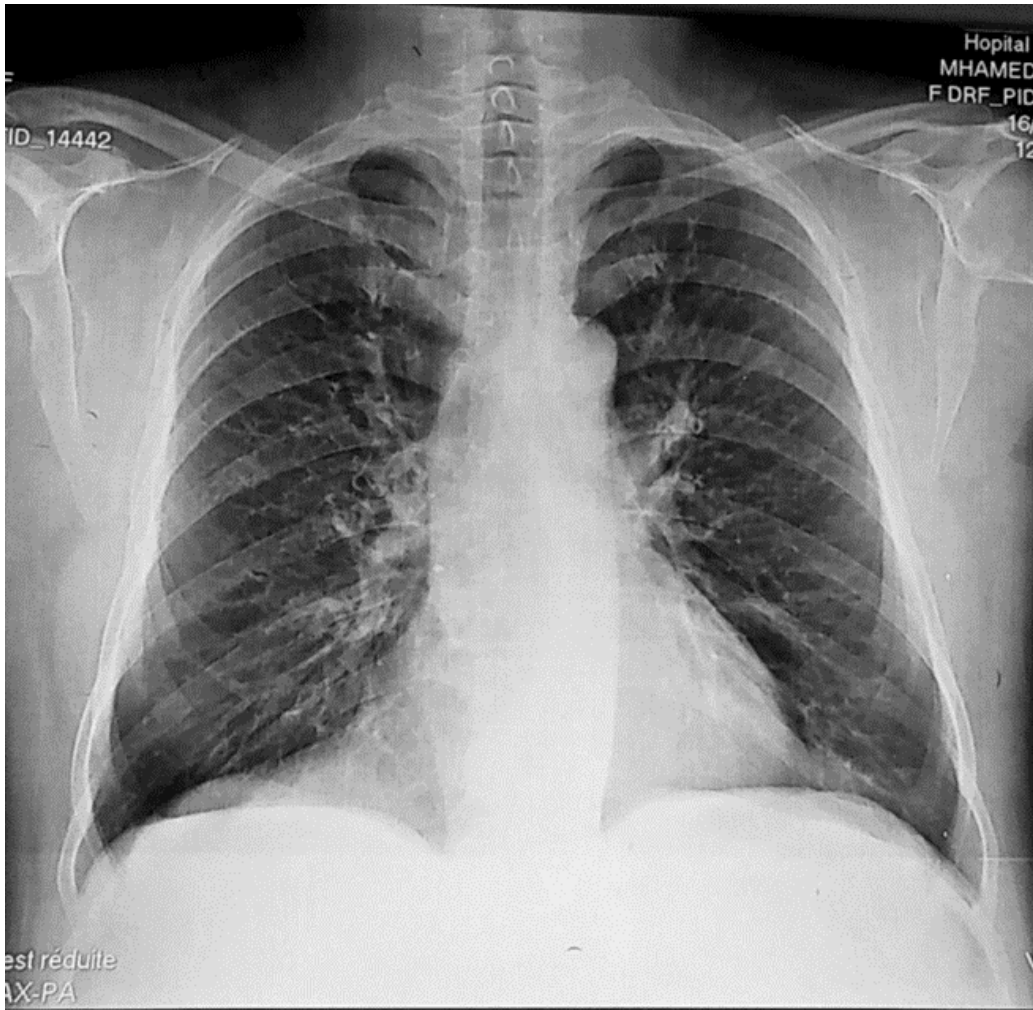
Chest X-Ray Showing, On A Slightly Distended Thorax, The Presence Of Finely Circumscribed Alveolar Images In The Lower Thirds Of Both Lung Fields, Along With Rail-Track Images In The Right Lower Thoracic Region.
